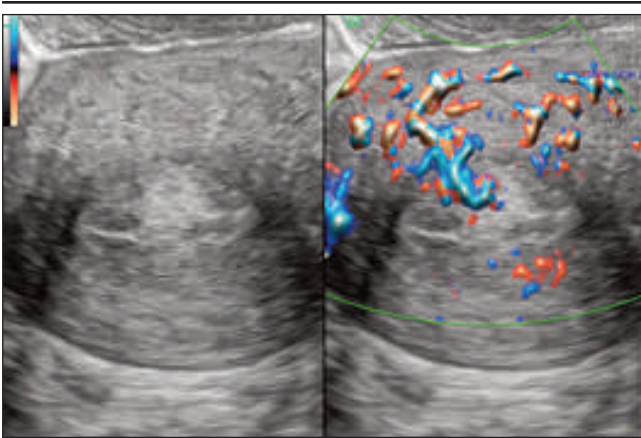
Endometrial polyp on 2D ultrasound and with HD low showing single feeding vessel
